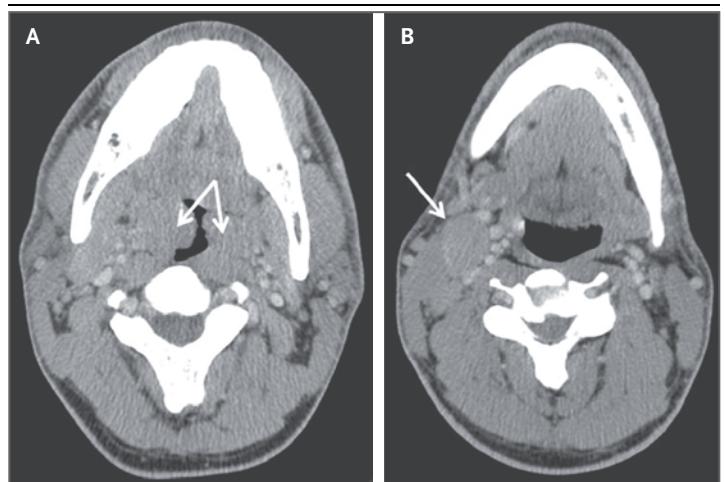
High-Resolution Computed Tomography of the Neck.
